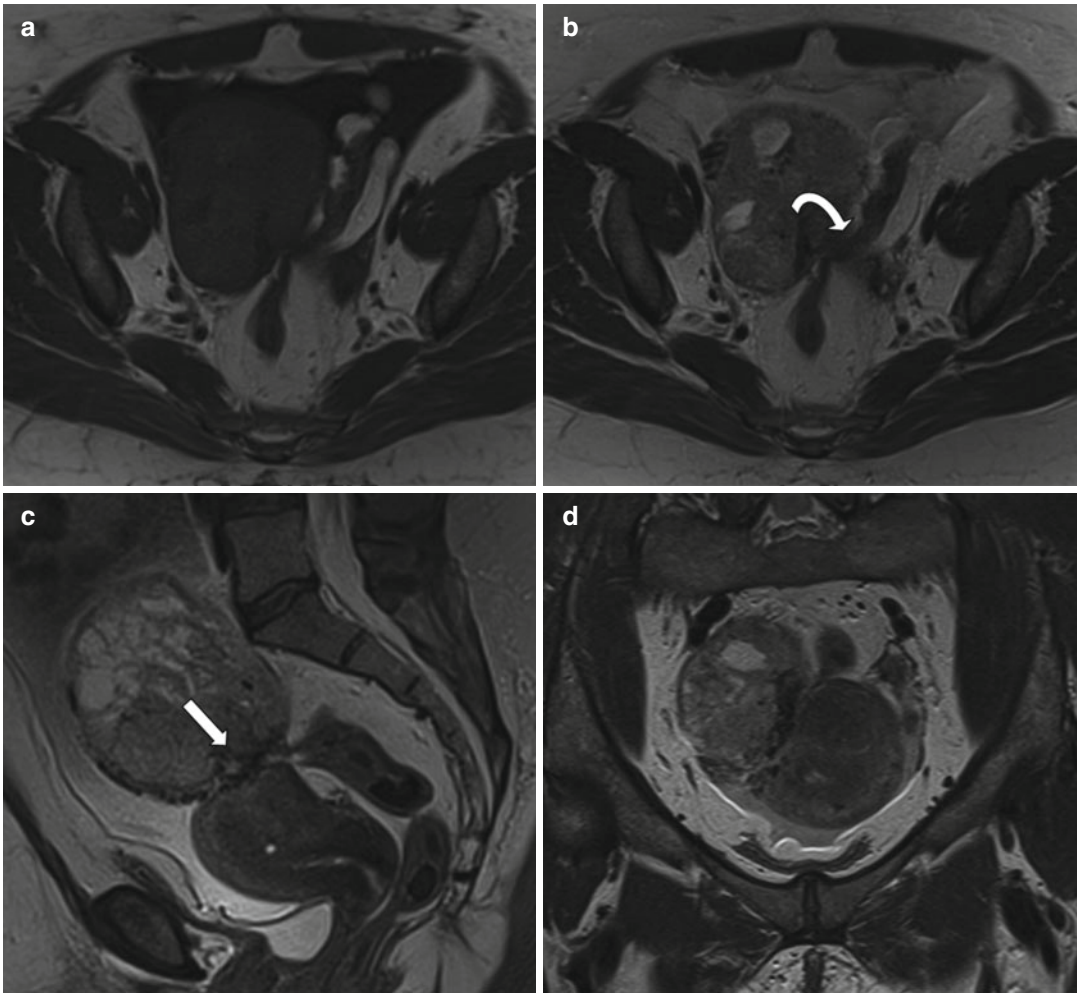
Grade 1 endometrioid carcinoma in a background of diffuse endometriosis. A 52-year-old lady with a large right-sided predominantly solid pelvic mass. This demonstrates low signal intensity on T1-weighted image (TR:519, TE:10; a) and heterogeneous signal intensity on
